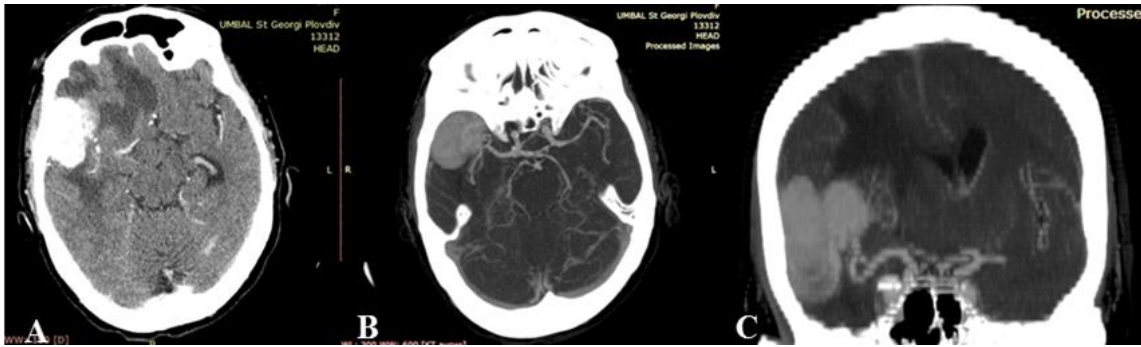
CT image of meningioma of the greater wing of the sphenoid bone: A) axial image with contrast enhancement; B and C) CT angiography demonstrating tumor's blood supply
